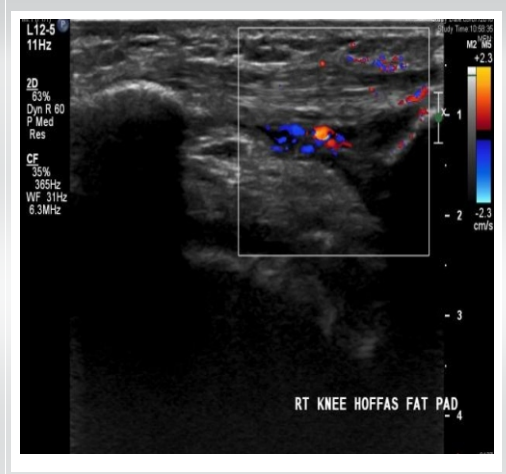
Focused ultrasound screening with Doppler.
